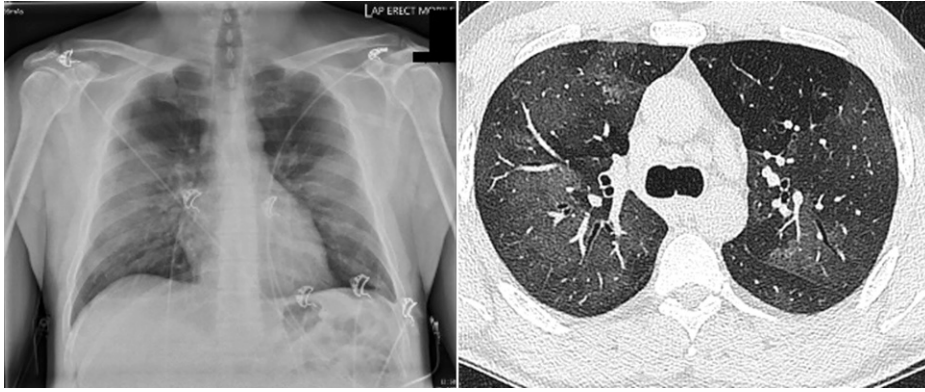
Chest x-ray and high-resolution CT of the chest showing bilateral pulmonary opacity. CT = computed tomography.
